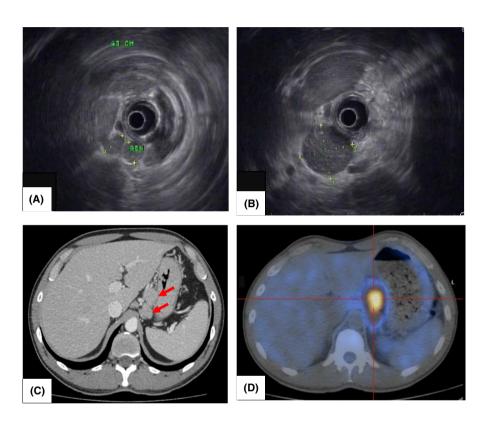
Perigastric adenopathic conglomerate in the region of the lesser gastric curvature and the celiac trunk shown in endoscopic ultra-sound (A, B) and contrast-enhanced CT (C), with high metabolic activity on PET/CT (D), performed in 2017.
